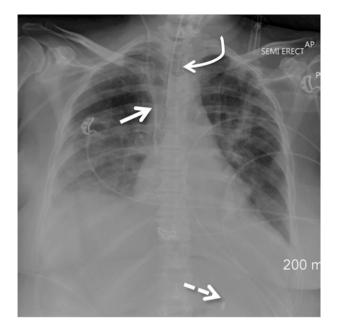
This is an AP chest radiograph taken in an ICU patient. Support lines and tubes are in satisfactory positions. Note the central venous catheter in the right internal jugular vein with its tip at the superior cavo-atrial junction (solid arrow). An endotracheal tube is also visible with its tip approximately 4 cm from the carina (curved arrow). The tip of a naso-gastric tube is suitably placed within the stomach (dashed arrow). Numerous external cardiac monitoring leads are also visible. Other findings include left lower lobe consolidation and atelectasis, perihilar vascular congestion and oedema, and a small right pleural effusion that is layering dependently given the semi-erect position
